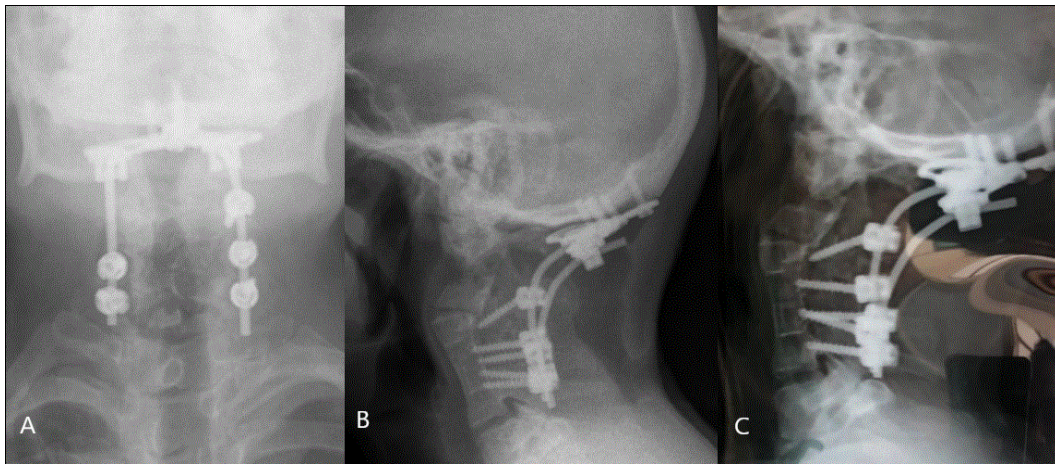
(A), (B) shows post-operative AP and lateral view of cervical spine. (C) radiograph taken at 3 months follow-up shows signs of fusion. Note: These x-rays have been photographed from films which may explain some visual distortion. The patients radiological and clinical status, however, was deemed satisfactory.
